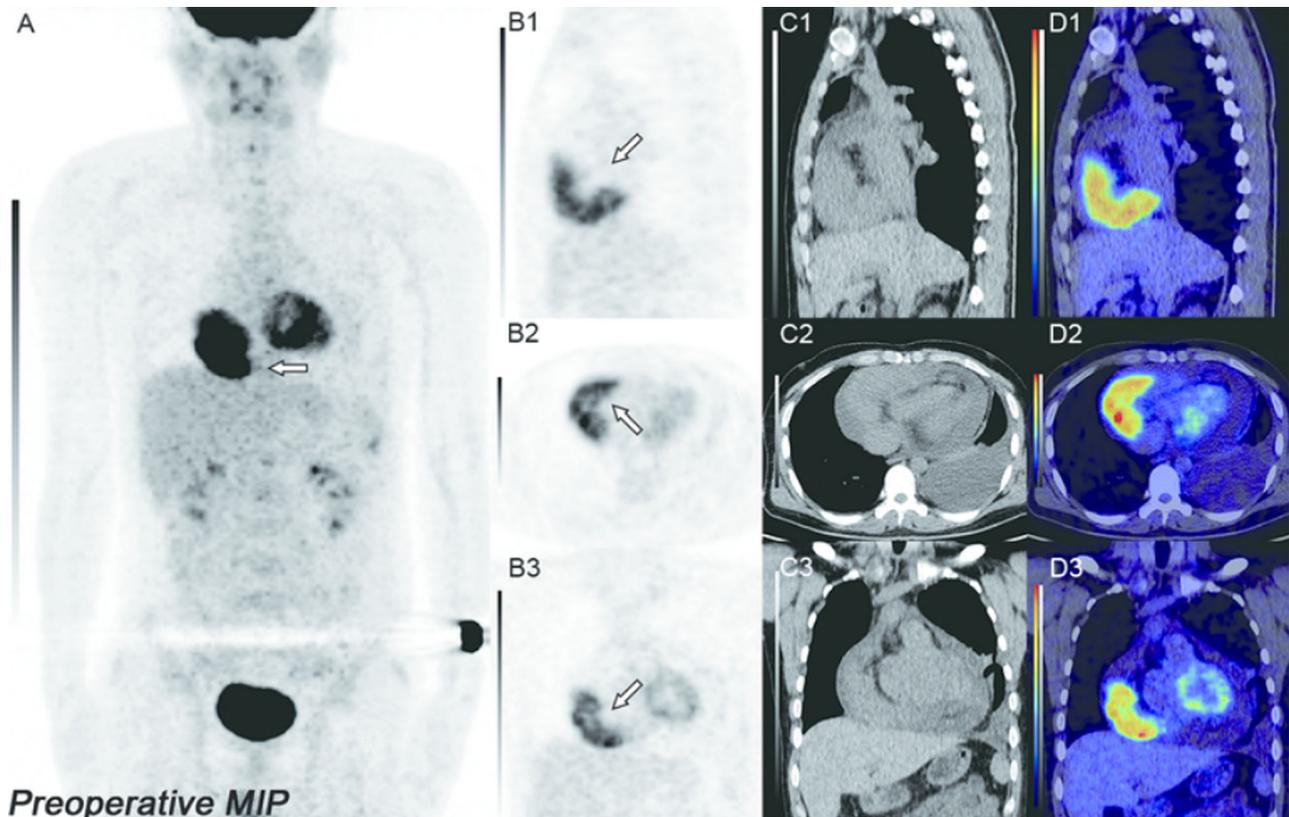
Preoperative ^{18}F -FDG positron emission tomography combined with computed tomography imaging. A Maximum-intensity-projection (MIP) image showing the tumor adjacent to the heart, which showed higher uptake of ^{18}F -FDG (white arrow, SUVmax 6.6) higher than the myocardium. B, C, and D Sagittal (1), transverse (2), and coronal (3) views of selected PET, CT, and fused PET/CT images showing a boomerang shaped tumor attached to the outer edge of the right ventricle.
